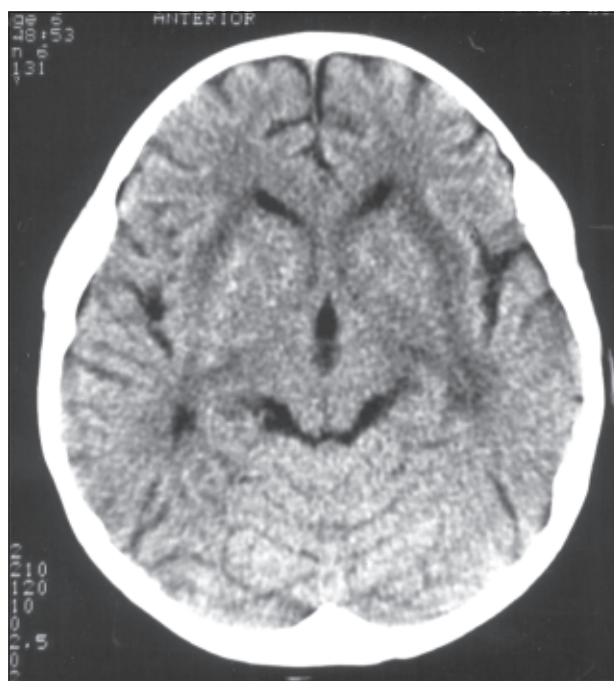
Non-contrast computed tomography scan on presentation showed hypodense areas in external capsules and both basal ganglia.
